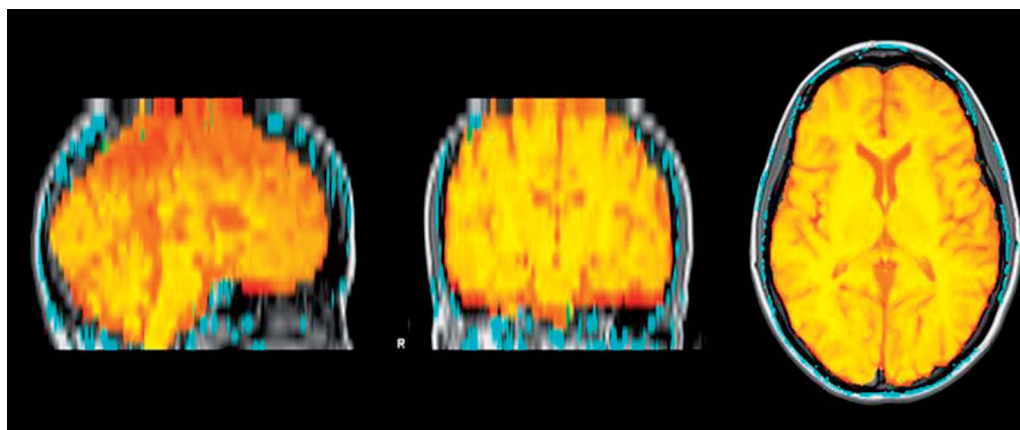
Brain extraction tool (BET), used to extract the brain and skull from magnetic resonance images.
